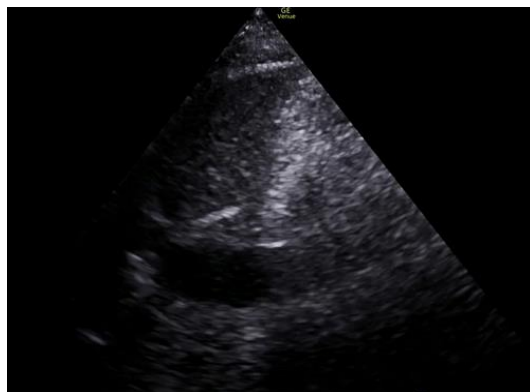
Inferior vena cava (IVC) view on POCUS showing a dilated, non-collapsible IVC without respiratory variation. This finding combined with the cardiac ultrasound findings in this hypotensive patient is suspicious for obstructive shock, likely secondary to massive pulmonary embolism.
